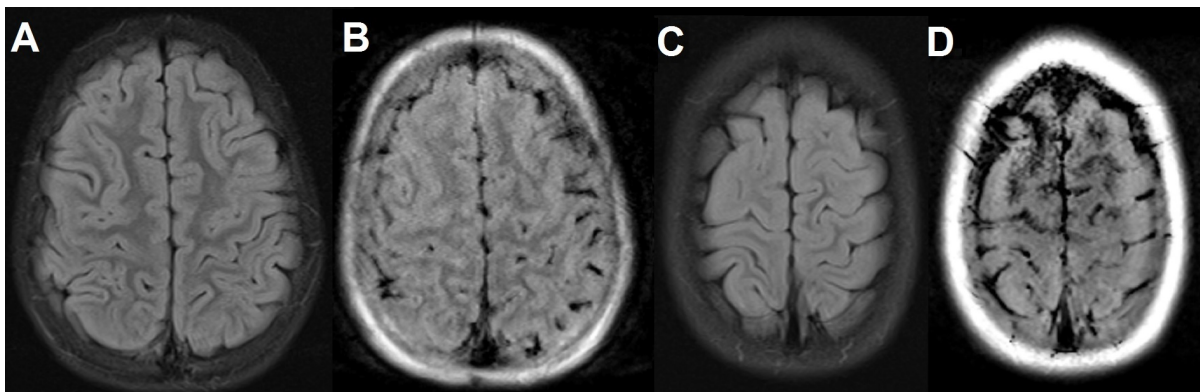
Conventional (A, C) and corresponding synthetic (B, D)  $T_2$ -FLAIR-weighted images with artefacts in synthetic images near the calvaria.
